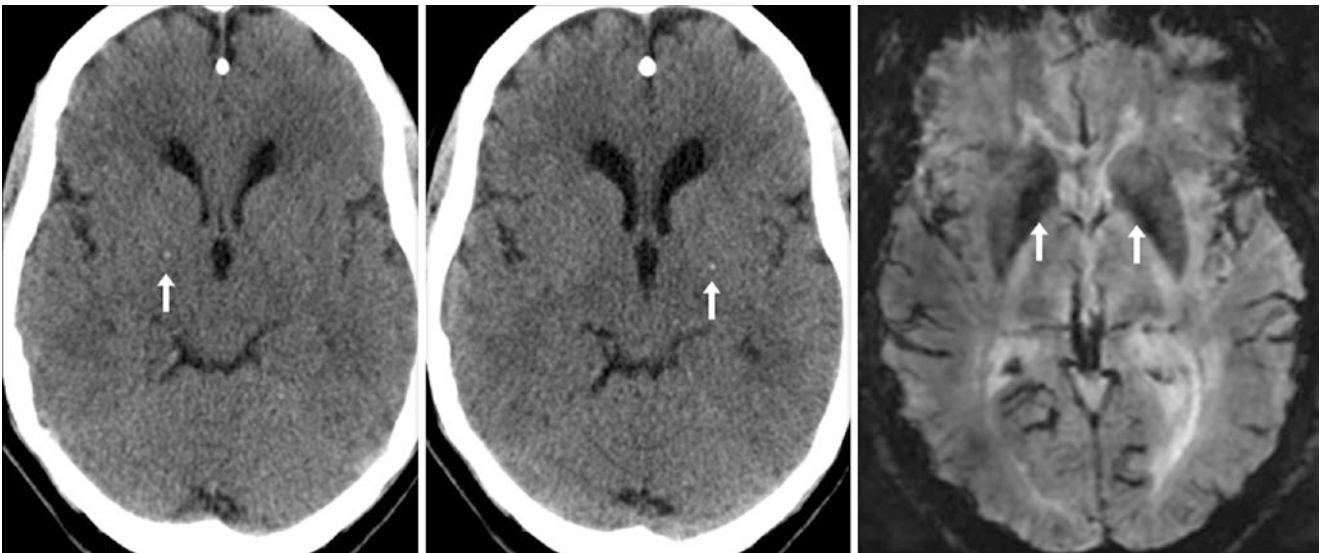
A 49 year old with bilateral very tiny BG calcifications (*arrows*) on NECT images (*left and middle*). On SWI MRI at 1.5T (*right*), there was a larger region of iron deposition as well, since the extent of the T2-dark signal on SWI is disproportionate to the degree of calcium on the NECT examination
